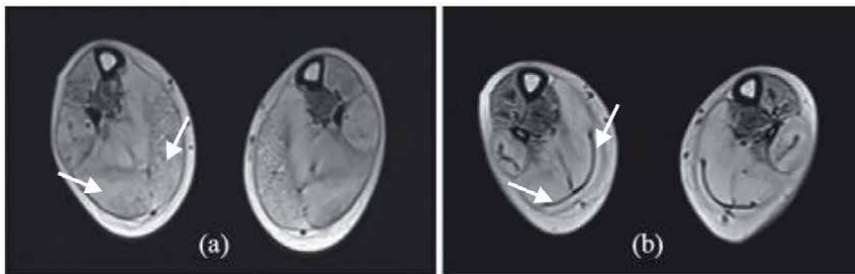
(a) MRI scan of vastus medialis and lateralis muscles (arrows) pre-cell therapy. (b) MRI scan of vastus medialis and lateralis muscles (arrows) post- cell therapy showing muscle regeneration.
